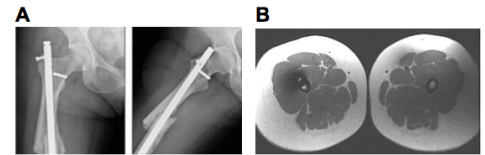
(A) X-ray image showing the location of the Orthopedic Implant (Titanium rod, approved for 3T MRI). (B) Axial turbo spin echo image with B_1^+ artifact near the implant due to interactions with the incident RF field (3T).
